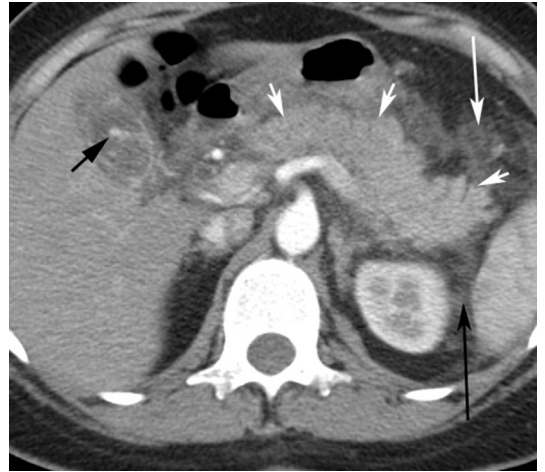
Acute interstitial edematous pancreatitis, CTSI 2. A CT image in the axial plane of a 34-year-old woman with acute onset of epigastric pain for 48 hours depicts a pancreas that enhances heterogeneously (short white arrows) with peripancreatic stranding anterior to the pancreas (long white arrow) and in the left anterior pararenal space (long black arrow). CT also demonstrates gallstones (short black arrow).
